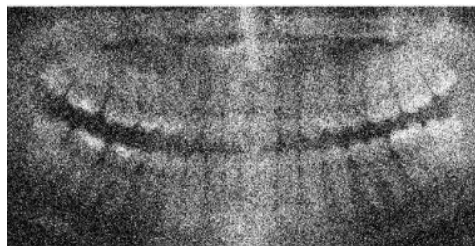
X-ray image added with Gaussian Noise
